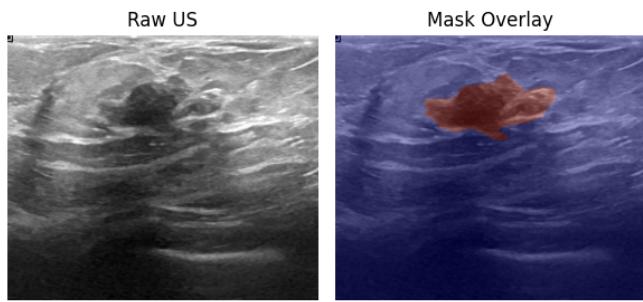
shows a raw B-mode ultrasound frame alongside its expert-annotated lesion mask. Our proof-of-concept pipeline crops each image to that mask and classifies it with a lightweight ResNet ($N = 130$ test cases), yielding 65 % accuracy, AUC = 0.55 (vs. 0.50 chance) and 0.11 s/image inference. This confirms end-to-end feasibility—segmentation followed by focused classification—but the modest AUC establishes a baseline: by incorporating spatial and channel attention in Aim 1 and Aim 2, we anticipate boosting AUC to ≥ 0.85 for robust subtype discrimination.
